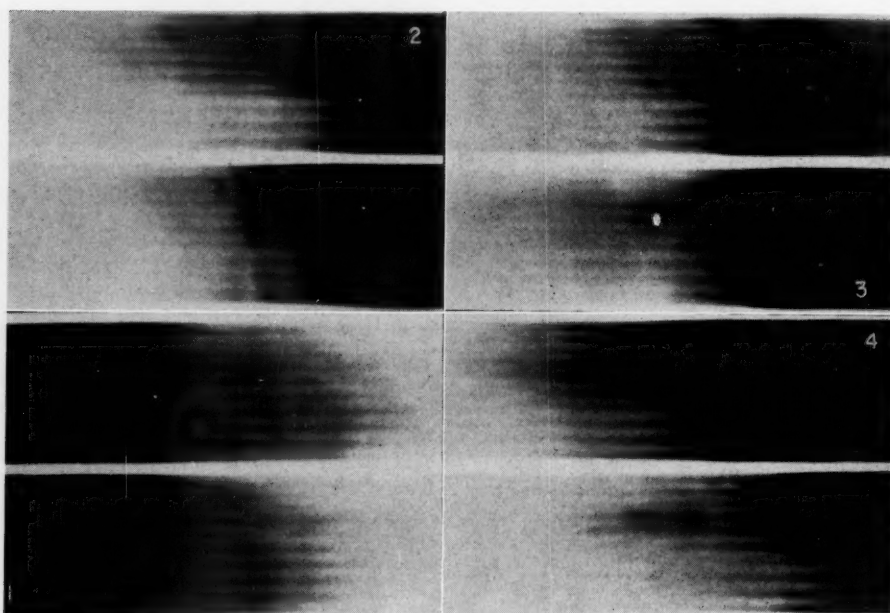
Enlargement of individual frames of roentgenographic kymogram shown in Figure 7. See text for explanation.
